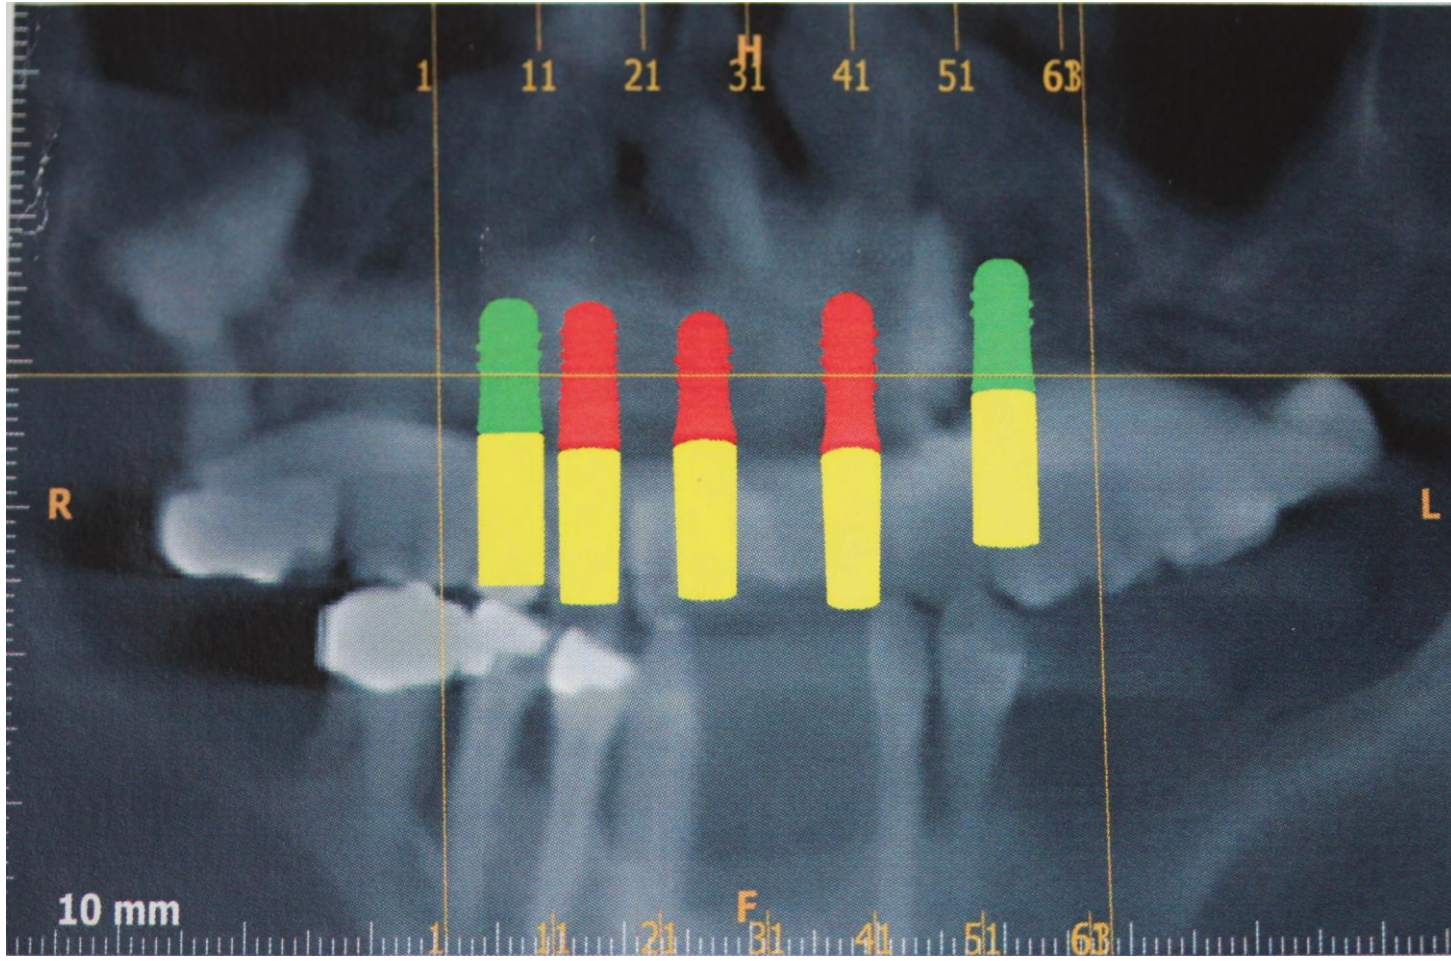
Planning of the implant placement on CBCT
